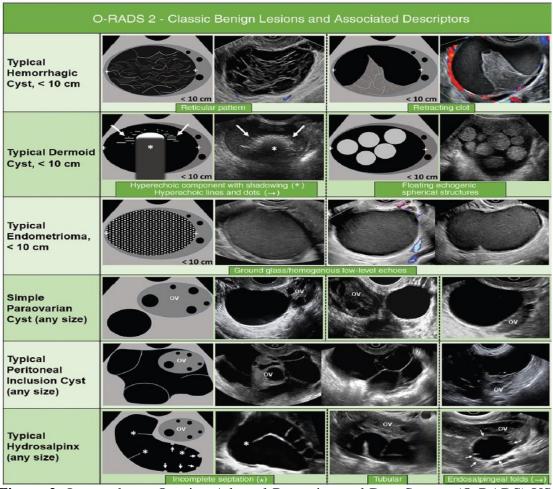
Image shows Ovarian-Adnexal Reporting and Data System (O-RADS) US category 2, classic benign lesions and associated descriptors. Ov = ovary. (7) O-RADS US 3: Low risk of malignancy (1% to <10%) - needs a referral to ultrasound specialist or gynecologist with a view to MRI (8)
